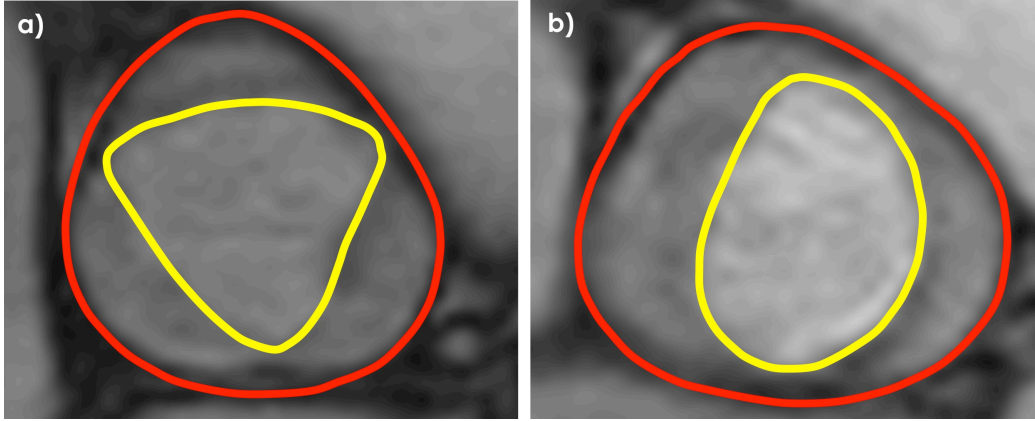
Example of orifice and aorta outline using the 2D cine MRI. a: TAV case; b: BAV case. In yellow: orifice outline; in red: aorta outline.
